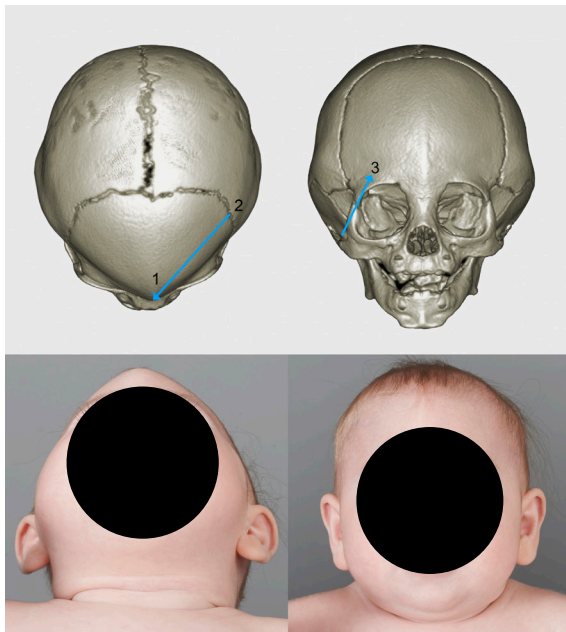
3D CT image (above) and photographs (below) of a child with MS. Typical features include a midline ridge (1), triangular forehead with medial displacement of the lateral part of the frontal bone (2) and hypotelorism with upslowing orbits (3).
